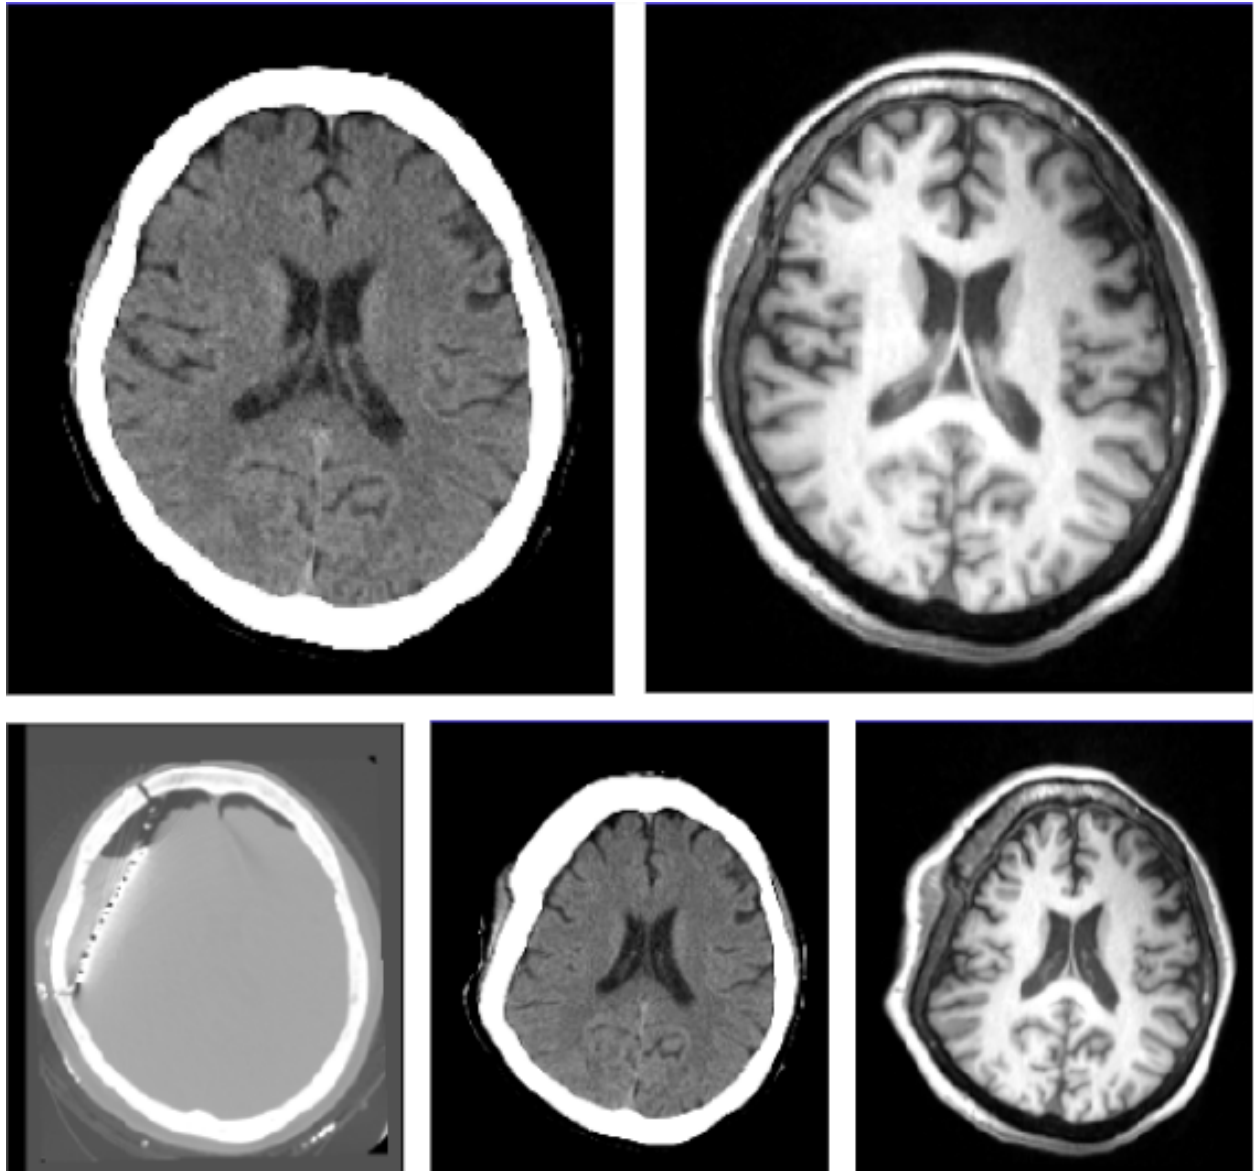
A single slice from one subject as the algorithm is applied. In the top row the original CT and MRI prior to implantation are shown. In the bottom row, the post-implantation CT is shown on the left, the nonrigidly registered CT in the center, and then on the right is the MRI after the transformation has been applied.
